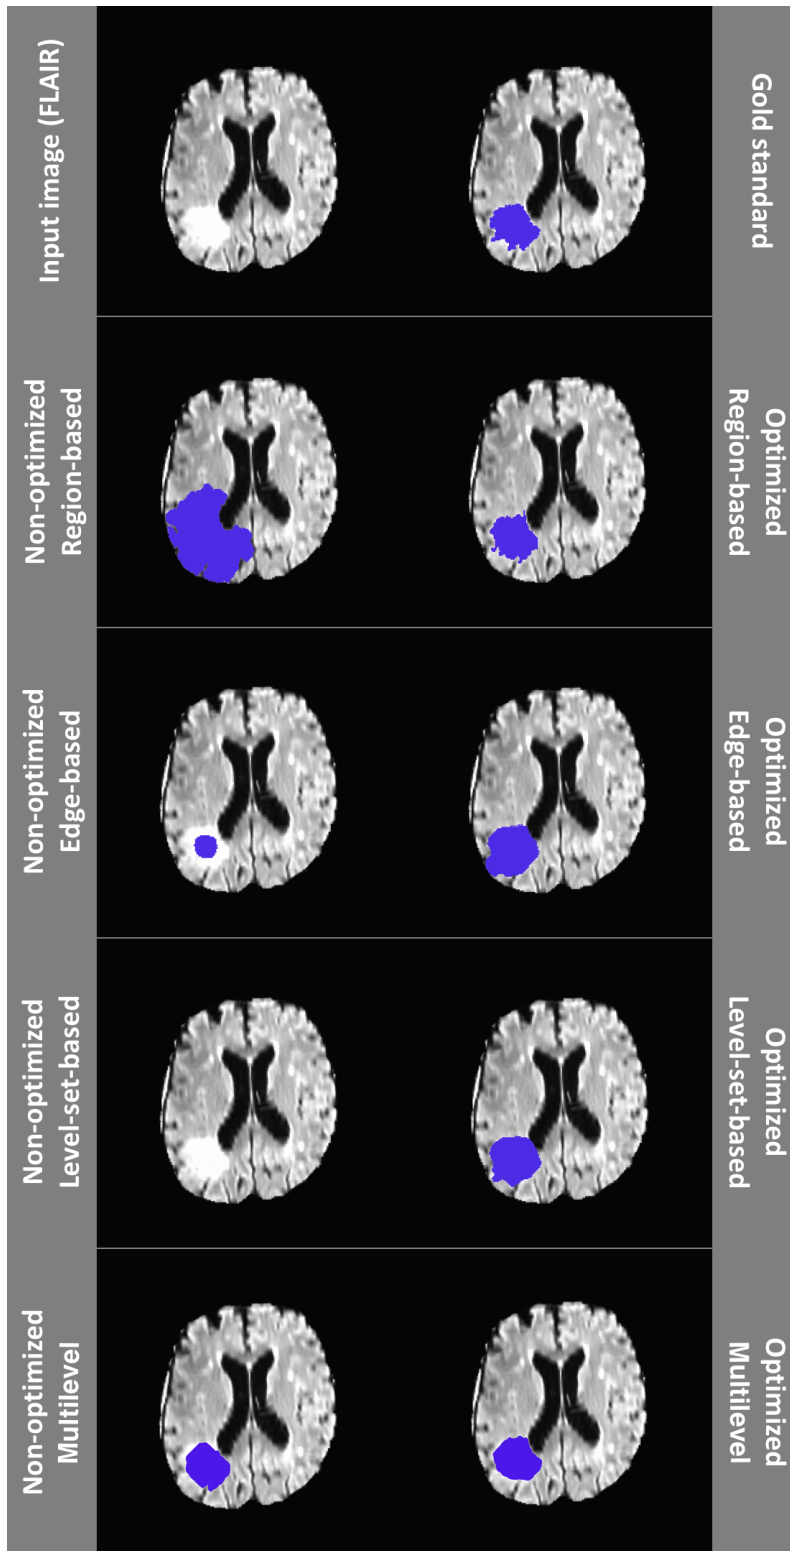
Comparative example (FLAIR) of resulting ROIs obtained for one subject, comparing the default (left) and optimized (right) parameters.
